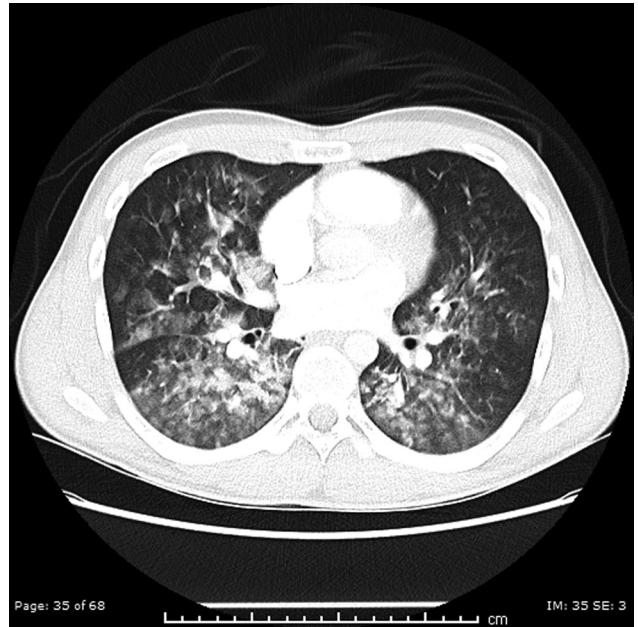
Case 4, chest CT: extensive ground-glass opacities. CT, computed tomography
